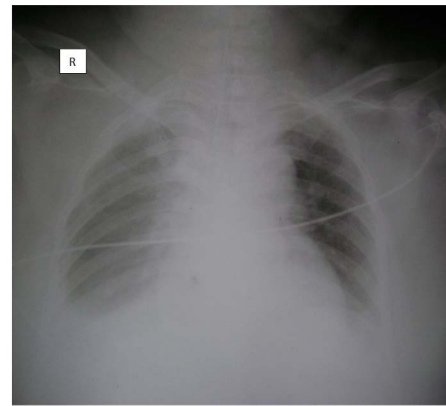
Radiograph showing bilateral pleural effusion.
